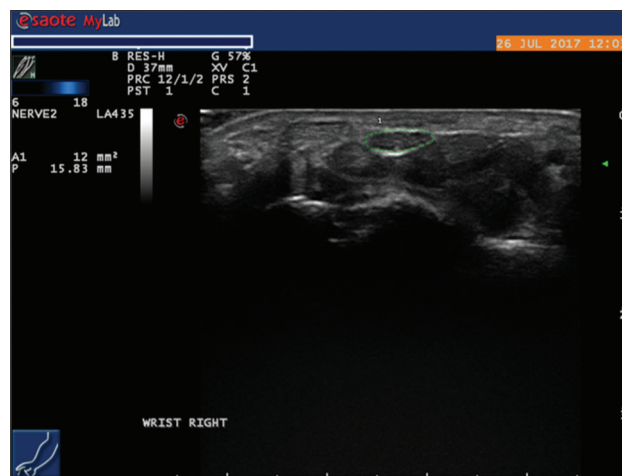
Ultrasound measurement of median nerve at wrist carpal tunnel (Green dash line circled)
